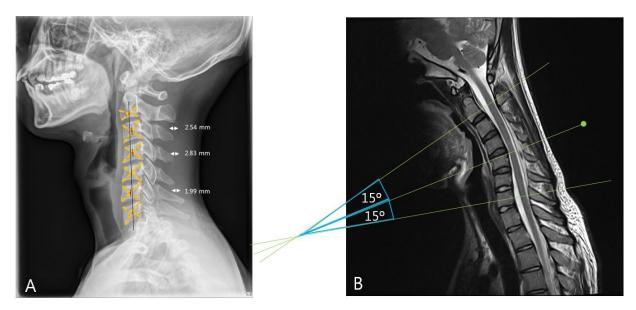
Cervical plain radiograph showed straightening of cervical spines with reversed lordosis Figure 1-B. T2 weighted image on cervical neck flexion, most severely tensioned spinal level was located between C4-5
